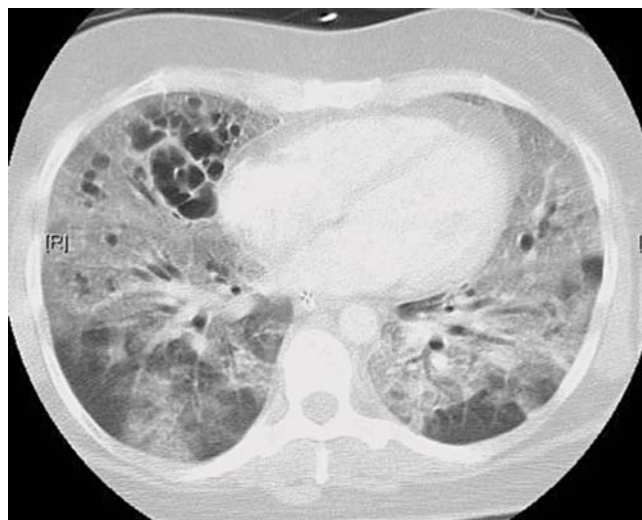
CT image through the midchest in a patient with ARDS receiving mechanical ventilation with PEEP. Parenchymal involvement is markedly inhomogeneous, with relatively normal areas in the dependent lung zones, widespread ground glass opacities in both lungs and intraparenchymal cystic air collections, primarily in the anterior portions of the right lung.
